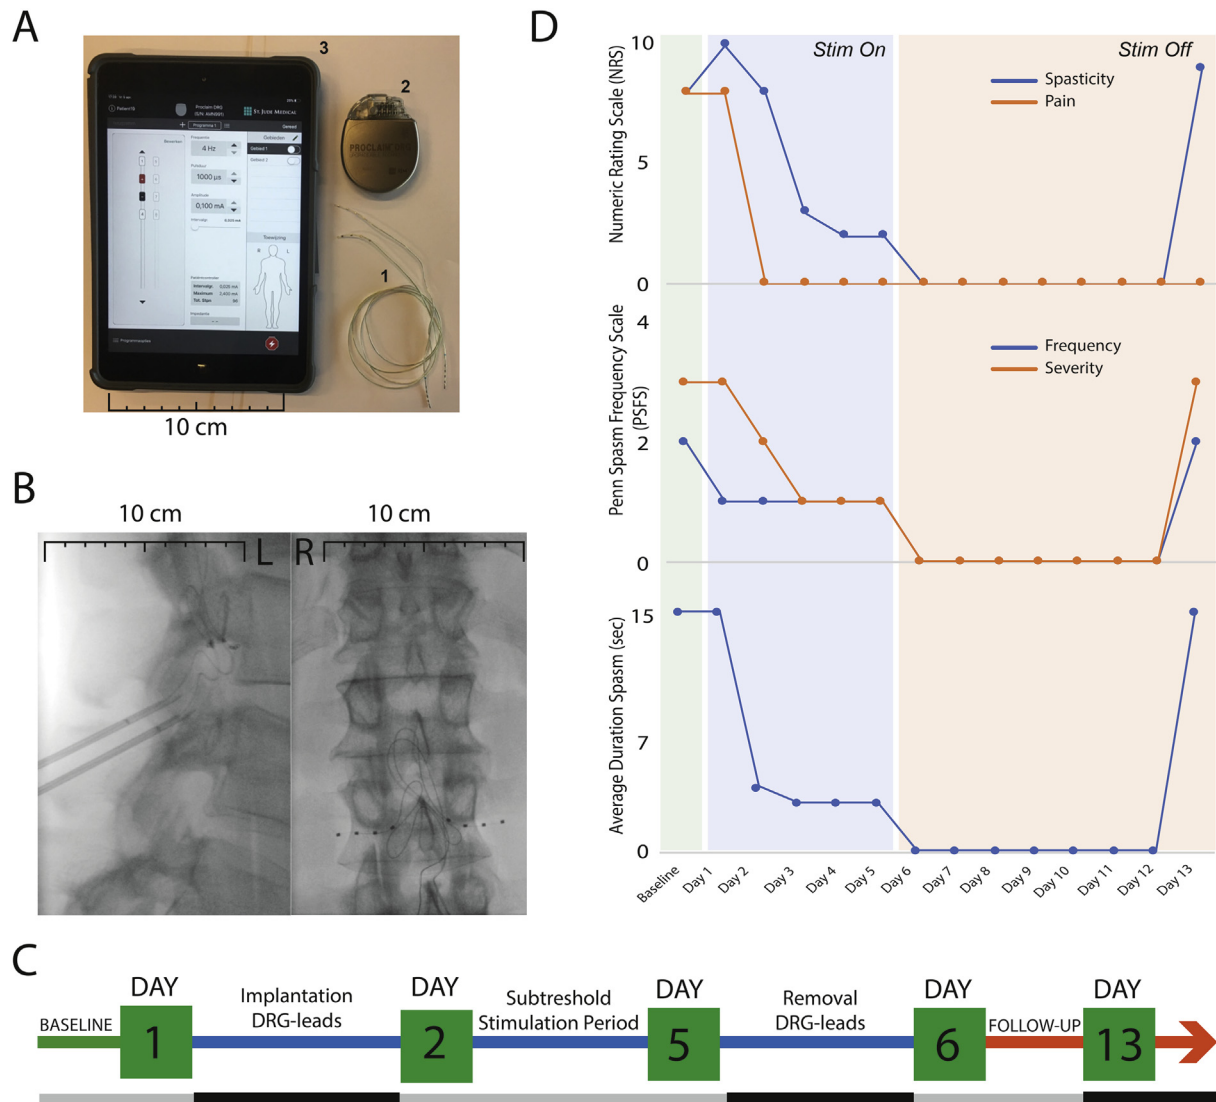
Overview of the case report as presented in this paper. A) The patient was implanted with conventional DRG-leads (1) as used for chronic pain treatment, connected to a pulse generator (2), which could be controlled with a clinician's programmer (3). B) Intra-operative X-ray images from a lateral (Left) and frontal (Right) view, showing the bilateral placement of the DRG-leads on the L2-level. C) Overview of the study design, with 2 EMG-measurements (day 1 and day 5), and a subthreshold stimulation period in between (0,1 mA, 4 Hz, 1000 μ s). Between day 6–13, the patient was followed-up. The grey line indicates the continuous self-reported measurements as collected daily. Clinical measurements were performed with the subthreshold stimulation on and the stimulation off (<30 min. on day 5 and 1-week post-stim on day 13), indicated by the black areas. D) Overview of the self-reported measurements (NRS, PSFS and average duration of spasm) from the baseline to day 13.
